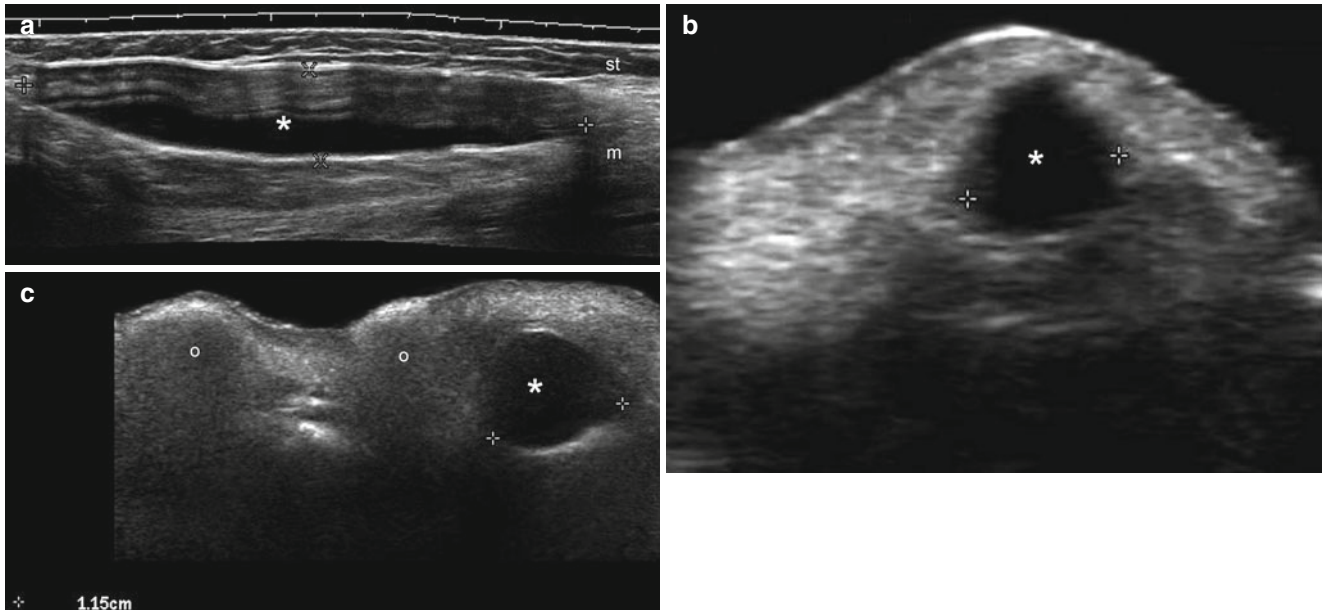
(a–c) Silicone implants. (a) Calf implant. Grey scale ultrasound image (longitudinal view, right calf) shows a well-defined, oval-shaped, anechoic structure (*, between markers) located between the subcutaneous tissue (st) and the muscle (m) layer. (b) Nasal implant in the tip of the nose (longitudinal view) demonstrates a well-defined round-shaped, anechoic structure (*, between markers) located between
